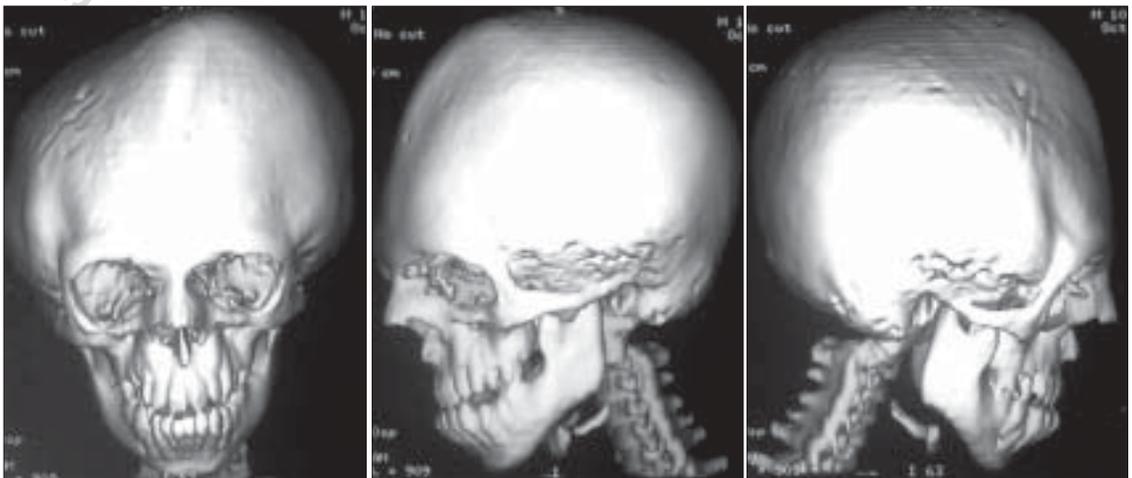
Frontal, left and right lateral CT scan of the skull revealing obliteration of sagittal and coronal suture lines with obvious bony continuity
